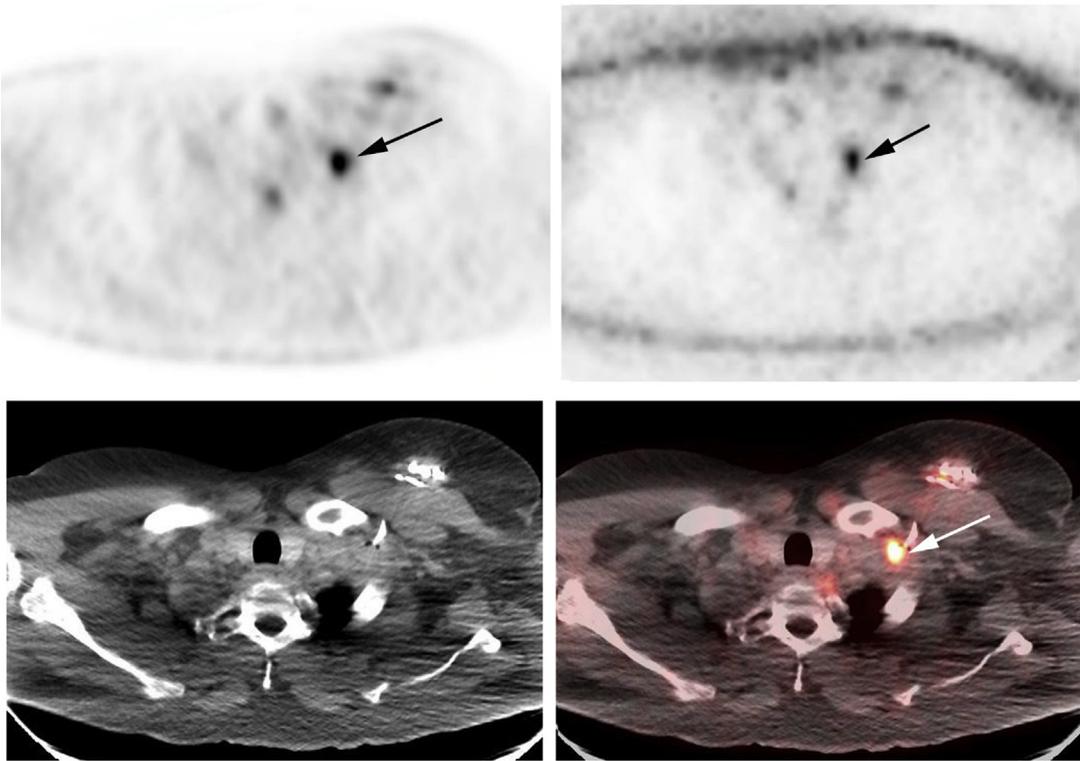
Attenuation-corrected (*top left*), non-attenuation-corrected (*top right*), CT (*bottom left*), and fused PET/CT images (*bottom right*) show prominent focal hypermetabolic activity associated with left chest wall ICD lead infection (*arrows*) in the subclavian vein with tiny air bubbles in a patient with methicillin-sensitive *Staphylococcus aureus* bacteremia.
